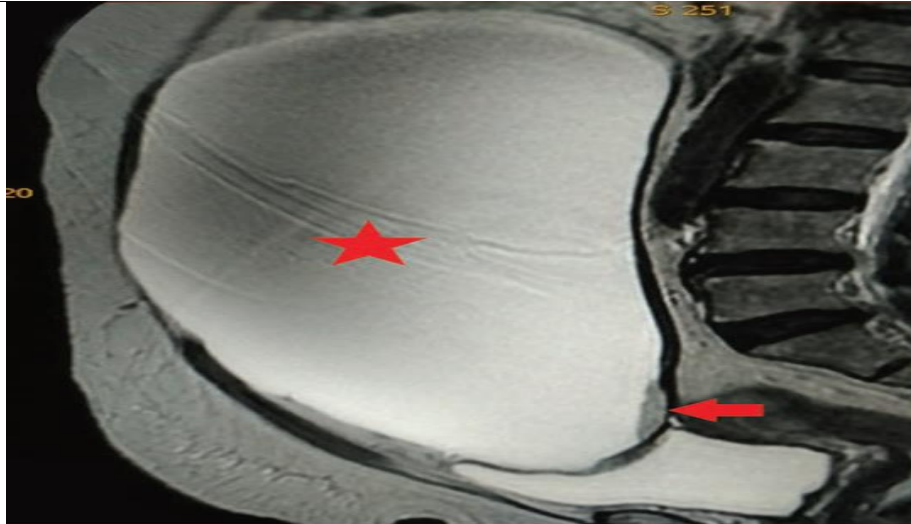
Sagittal T2-W MRI demonstrating a large well-defined thin walled unilocular cystic lesion (star) arising from right ovary. Small mural nodule is visualized (arrow). Findings could represent right ovarian cystic neoplasm (possible ovarian serous cystadenoma). MRI, magnetic resonance imaging; T2-W, T2-weighted.
